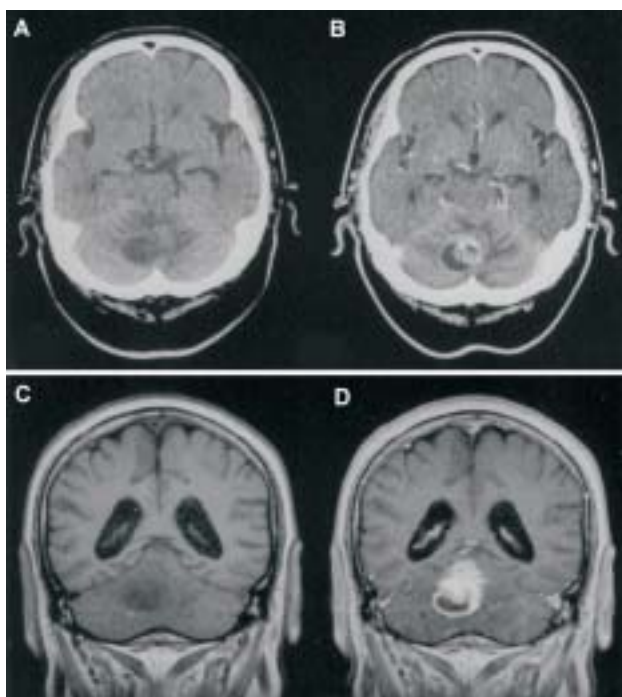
Computed tomography scans on admission showing a round cystic mass (A) with good enhancement in the vermis of the cerebellum. (B) T1-weighted magnetic resonance images (C) and with gadopentetate meglumine (D) showing round cystic mass with multiple nodules and ring-like enhancement. There is mild obstructive hydrocephalus.
